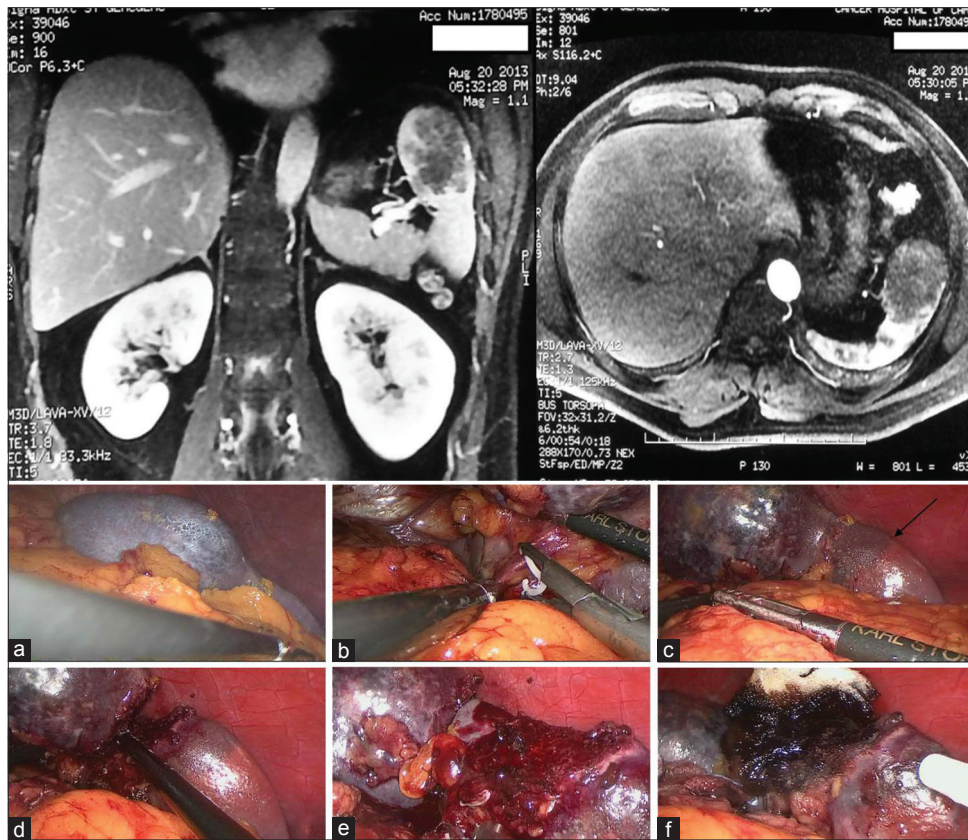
The solid mass in the upper and intermediate pole of the spleen revealed by preoperative magnetic resonance imaging and clearly visible position of the vessels dominating the tumor relative to hilar vessels (upper two panels). (a) The mass was located in the upper and intermediate pole of the spleen in exogenous growth. (b) The Hilar vessels dominating the position where the mass was located were severed and occluded after being crippled, disposable isolated splenic vascular tumor site after clipping off. (c) An ischemic demarcation line appeared (arrow). (d) The mass and part of normal spleen were resected along the ischemia line. (e) No active bleeding in the wound after the resection. (f) The wound was treated by medical adhesive bandages and hemostatic gauze.
